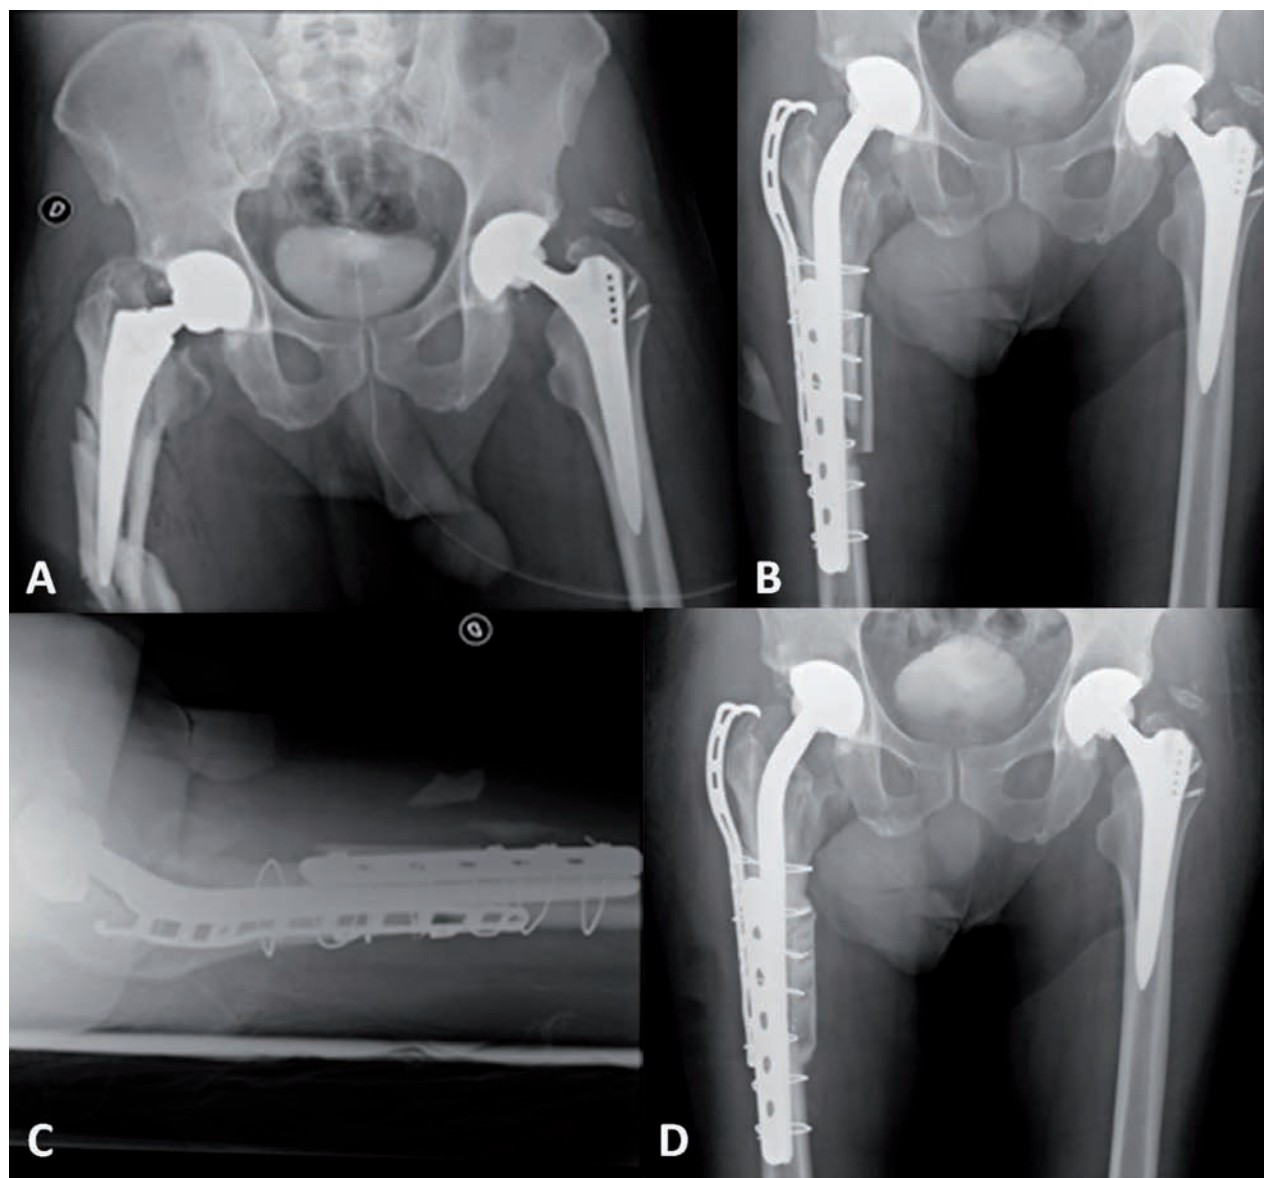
Type B3 right periprosthetic fracture. A; preoperative x-ray. B and C; postoperative x-ray after revision of the stem and positioning of plates, cables and autologous cortico-cancellous bone graft. D; x-ray 18 months after trauma with fracture consolidated.
